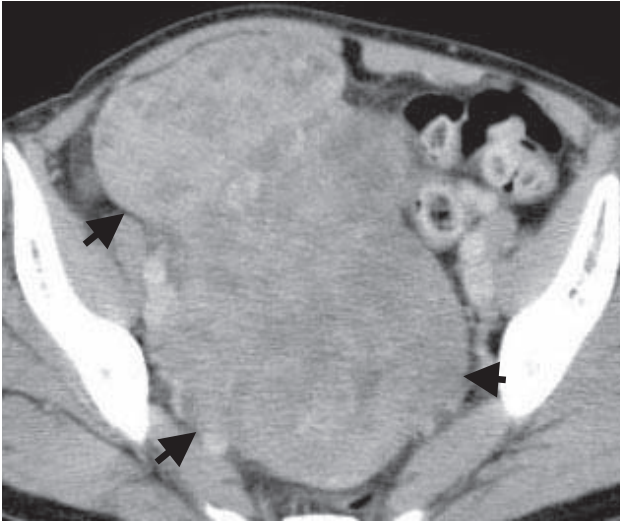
Contrast-enhanced axial CT of the pelvis. Contrast-enhanced axial computed tomography scan of the pelvis demonstrates the mass (arrows), which is enhanced heterogeneously.
